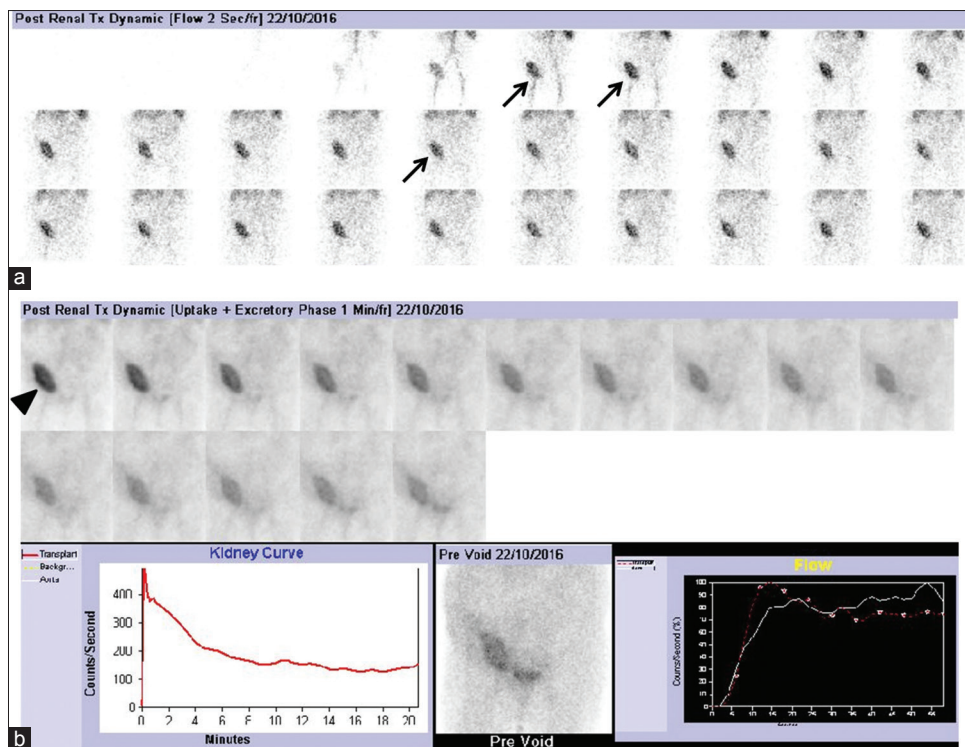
On open reexploration, single-photon emission-computed tomography findings were confirmed, and a large subcapsular hematoma was deroofed and hemostasis achieved resulting in improved graft function, creatinine levels (2.4 mg/dl on day 4 and 1.2 mg/dl on day 5), and good urine output. Poststabilization, ^{99m}Tc diethylenetriaminepentaacetic acid was reperformed on day 5, revealing prompt perfusion to graft in the right iliac fossa (Fig 4a-arrows) with good cortical tracer uptake and drainage (Fig. 4b, arrowhead) and significantly reduced background tracer activity compared to day 2 study
